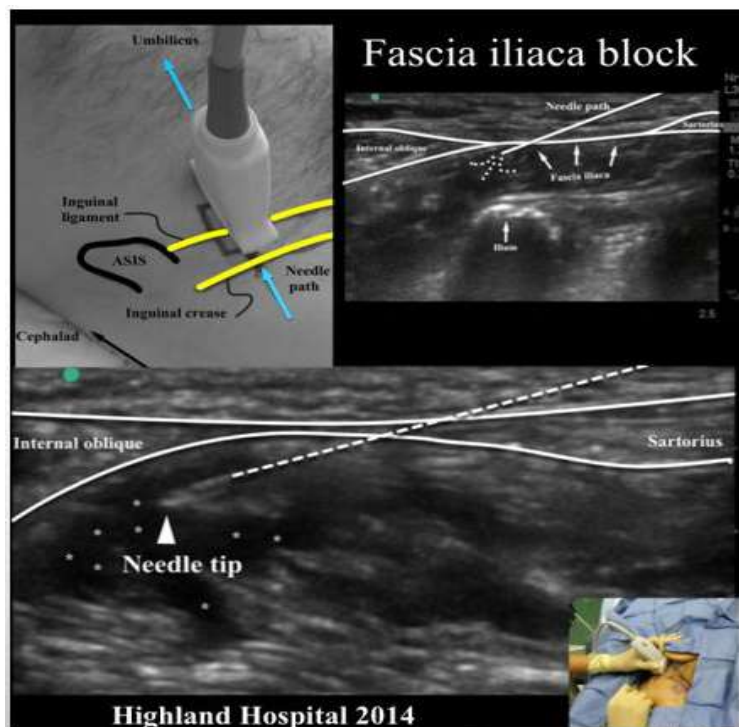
Ultrasound image of front of thigh at level of groin crease, to demonstrate injection of drug for FICB
